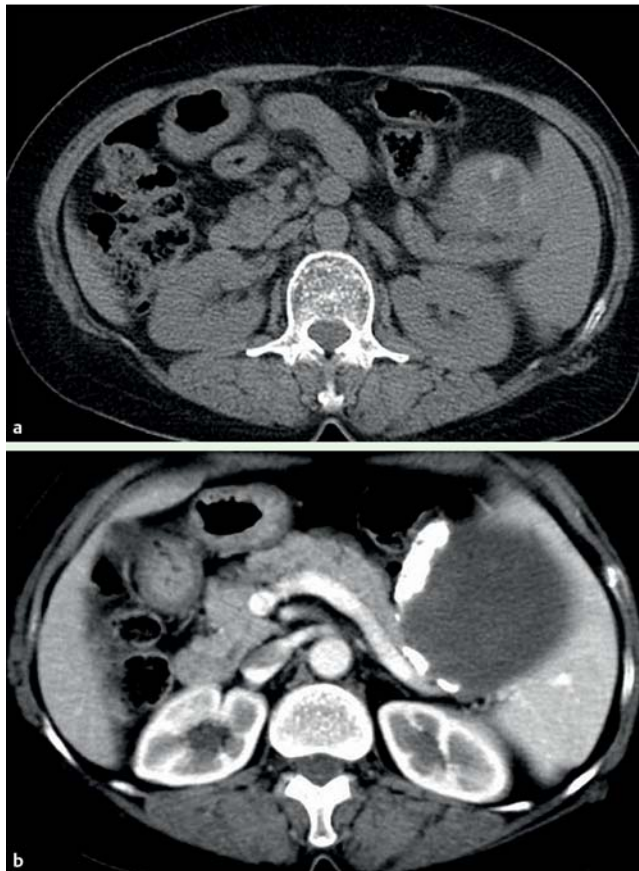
Abdominal computed tomography (CT) revealed a lobulated nonenhancing cystic lesion with: a intrinsic heterogeneous hyperdense areas; b thick peripheral wall calcification.
